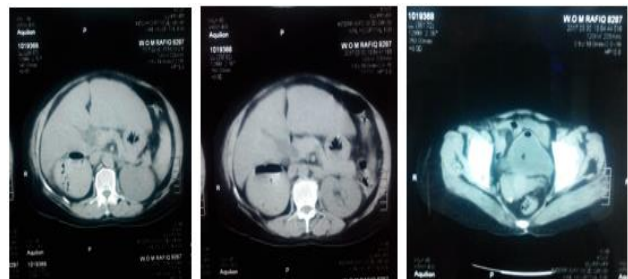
(a) Computed tomography (CT) image showing air level extending to right perinephric area. (b) showing air level involving right renal parenchyma. (c) CT image showing hydroaeric level and pneumobladder at the level of bladder wall.
